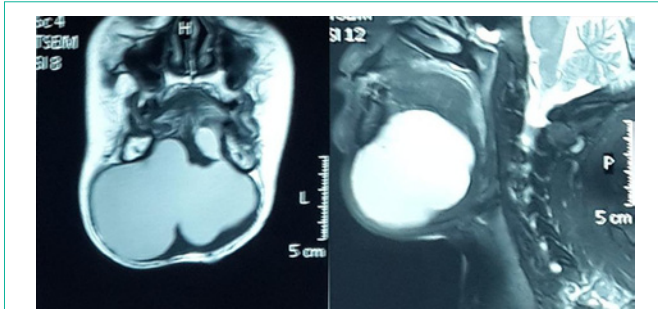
MRI imaging of floor of the mouth dermoid cyst.
